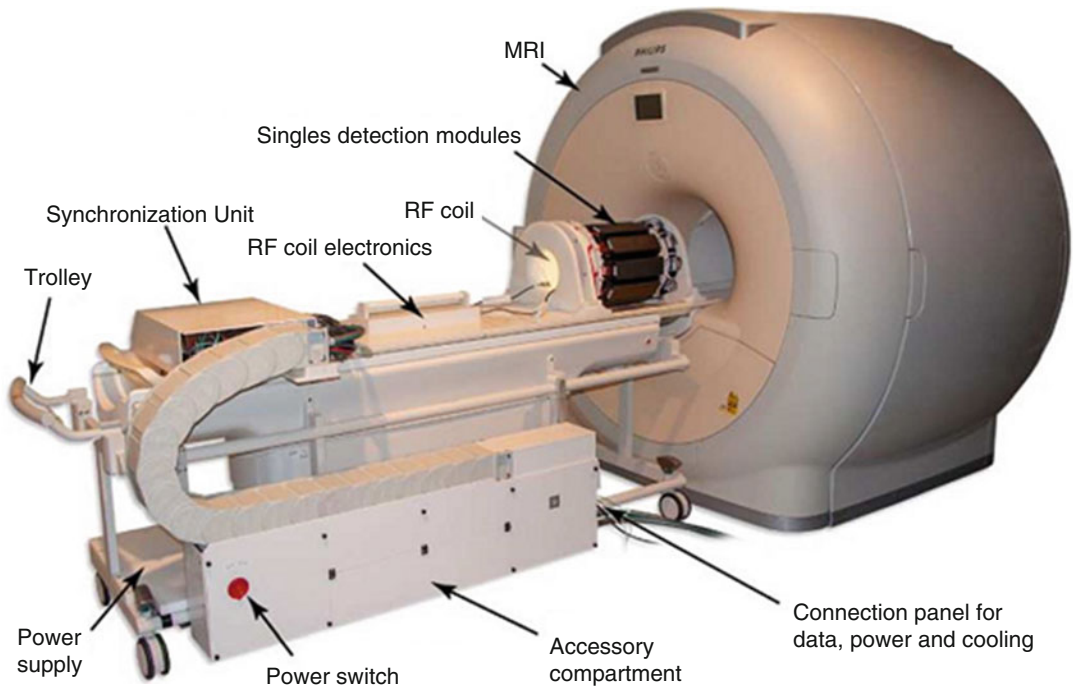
The PET/RF insert “Hyperion II[®]” mounted on the patient table of a clinical 3 T MRI system (gantry cover removed). The single detector module is described
